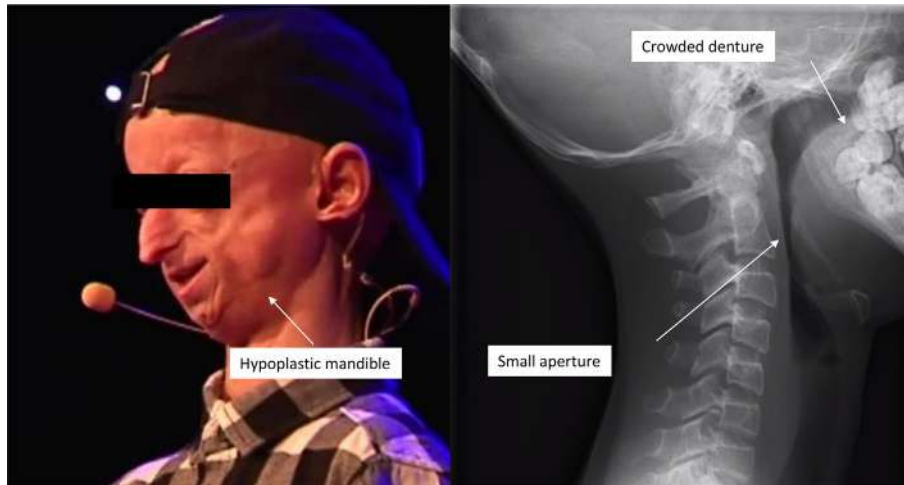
Profile picture of the patient and profile x-ray of the cervical spine, tongue base and denture.
